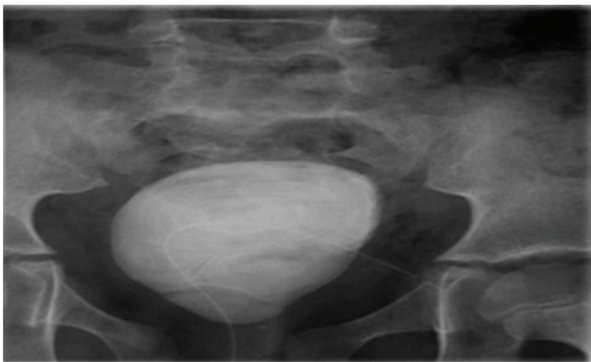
Preoperative pelvic x-ray: Highly calcified mass of smooth surface in the pelvic area.
